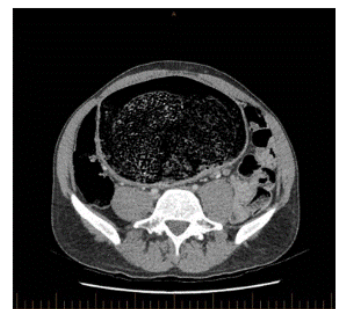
Axial view of CT image of abdomen
